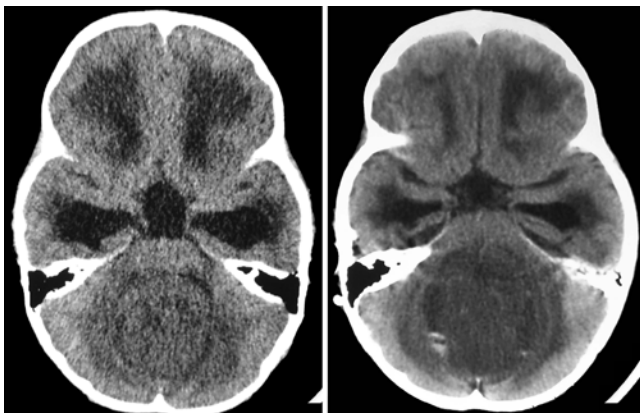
Case 7. Axial CT scans obtained before (left) and after (right) shunt placement showing UTH after shunting in a patient with medulloblastoma. Note the obliteration of the quadrigeminal and ambient cisterns.
